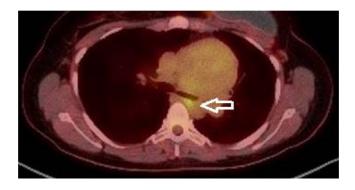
Small focus of localized FDG uptake corresponding to soft tissue in contact with the posterior aspect of the distal left main bronchus, suggesting encasement of the bronchus by the large mediastinal mass.
